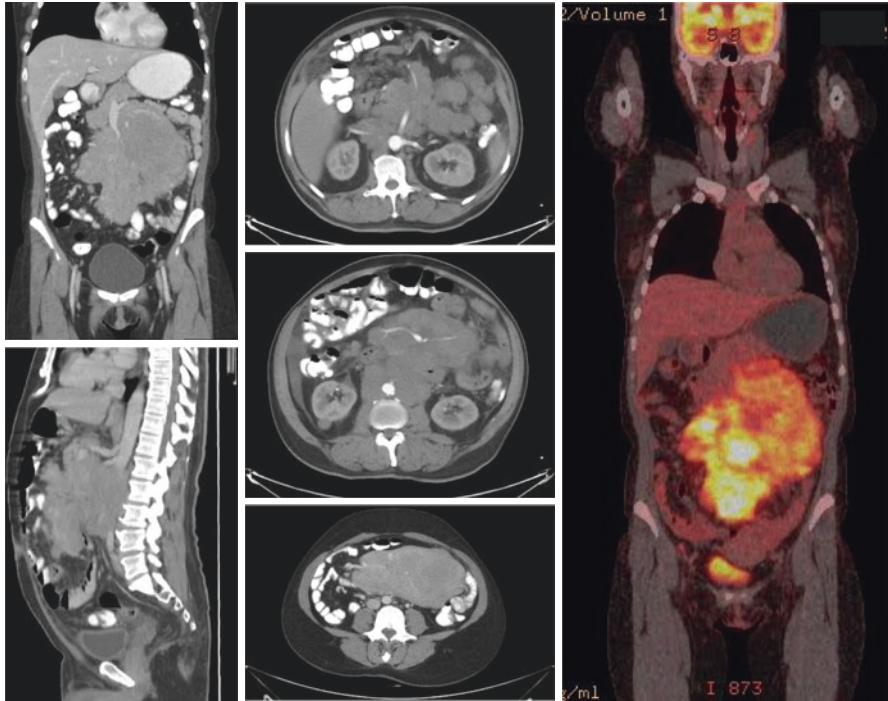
A 46-year-old female patient, complaining of abdominal pain for 3 months. CT shows a large volume abdominal mass, characterized by multiple confluent mesenteric lesions that may represent lymph node clusters, involving the superior mesenteric vein and its branches and the duodenal arch, with wide contact with the head of the pancreas. Image-guided biopsy revealed the diagnosis of diffuse large B-cell NHL. Staging PET-CT confirms tomography findings (SUV max: 14.8), with additional finding of multiple focal areas in the axial and appendicular skeleton, compatible with lymphoproliferative disease in activity
